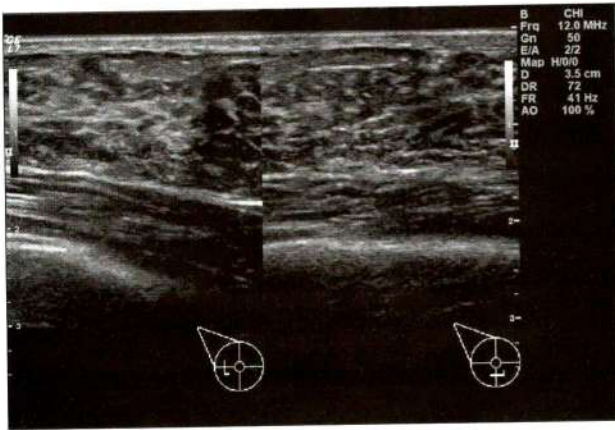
Ultrasound finding show fibroglandular tissue at the retroareolar area of the left breast.
